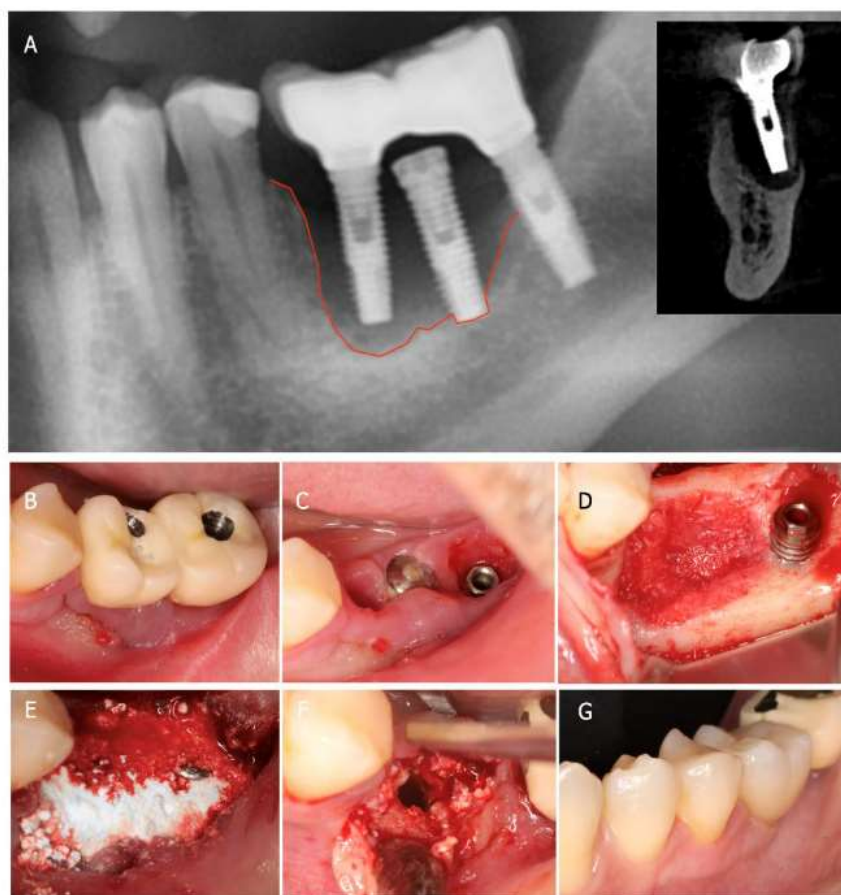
Mandible 1<sup>st</sup> left molar. A- initial radiograph demonstrating bone loss around the implants, B- clinical presentation of the current prosthetics and surrounding soft tissue, C- removal of the infected implants, D- bony defect resulting, E- BA placement into the bony defect, F- implant placement, and G- new prosthetics placed on the new implants.
